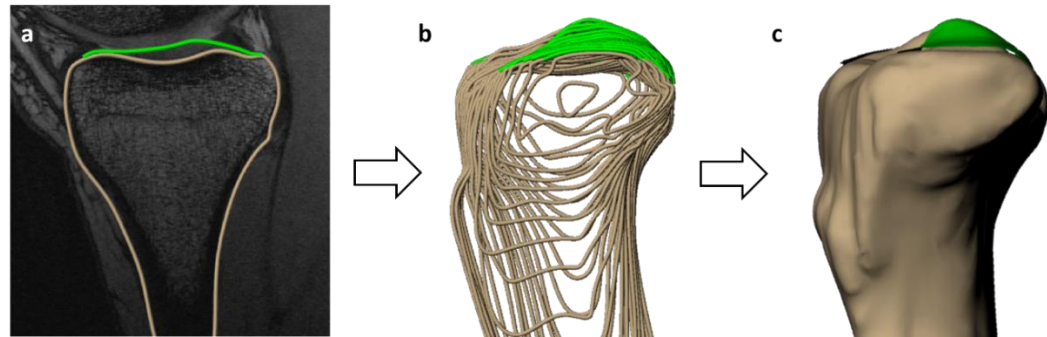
3D joint model creation from MRI (sagittal view, left knee). Image shows a) segmentation of articular cartilage and bone in a single MRI slice, b) stacked wireframe model of segmented surfaces, and c) 3D surface mesh model of the tibia and tibial cartilage.
